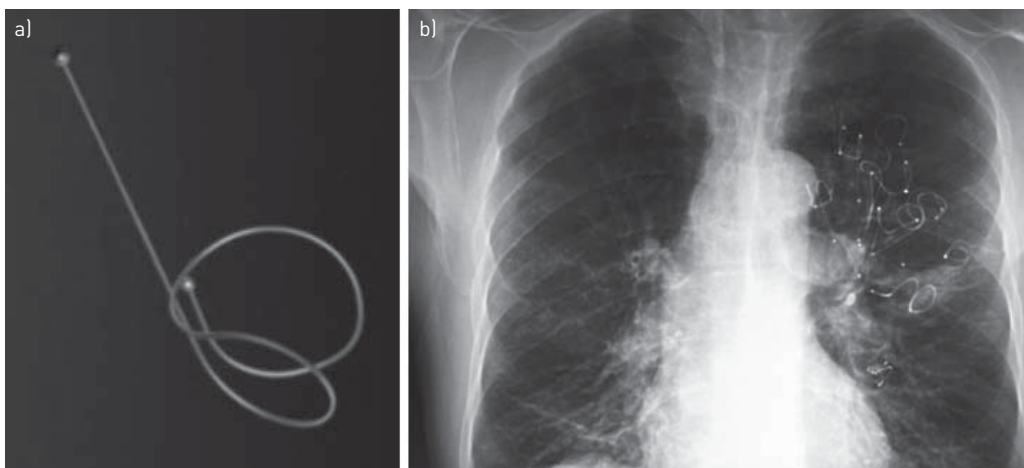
a) An example of a single coil used for the procedure. b) A chest radiograph from a patient showing the positioning of eight coils after the procedure.
